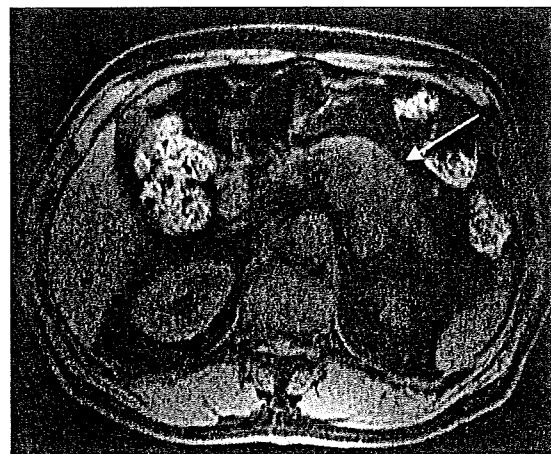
Abdominal magnetic resonance T1-weighted short T1 inversion recovery (STIR) imaging of Case 3 before treatment. This case was not a suitable candidate for intravenous iodine contrast use because of allergy. Tumor is detected in the pancreatic body (arrow) with weak contrast.
